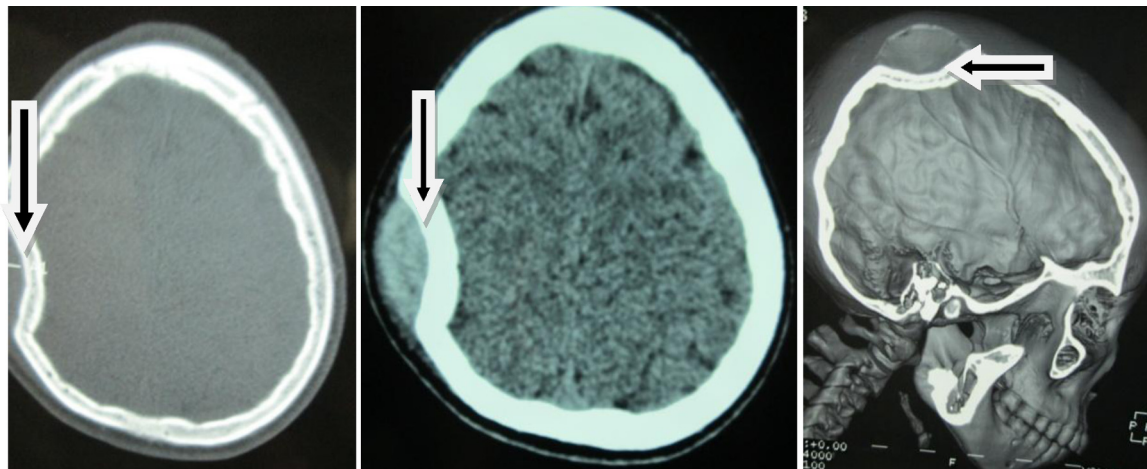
CT scan: depression of the right parietal bone by a throw mass of 3 kg (arrows).
